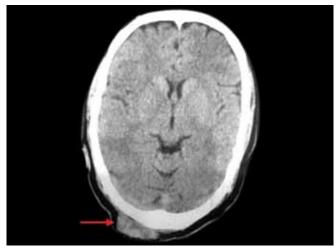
Computed tomography scan of head showing a 4 cm, noncalcified, uniformly enhancing well-defined soft-tissue mass in occipital region (red arrow), evidence of osseous erosion or invasion not seen
